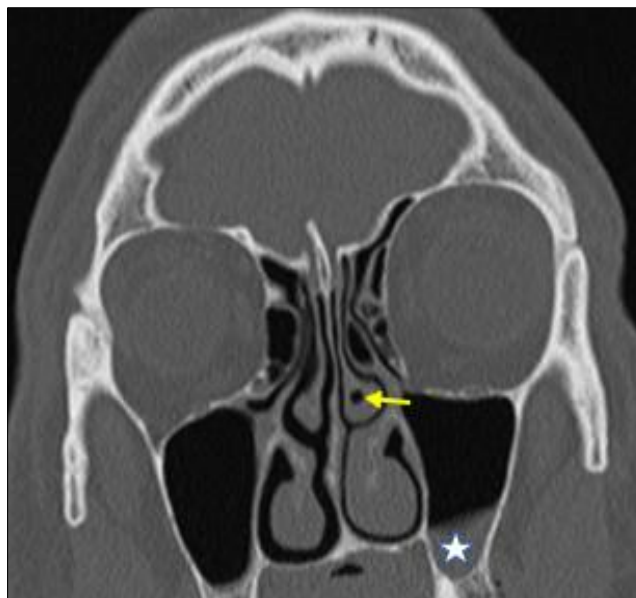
Coronal CT section showing left sided concha bullosa (Yellow arrow) and left maxillary sinusitis (White star).
